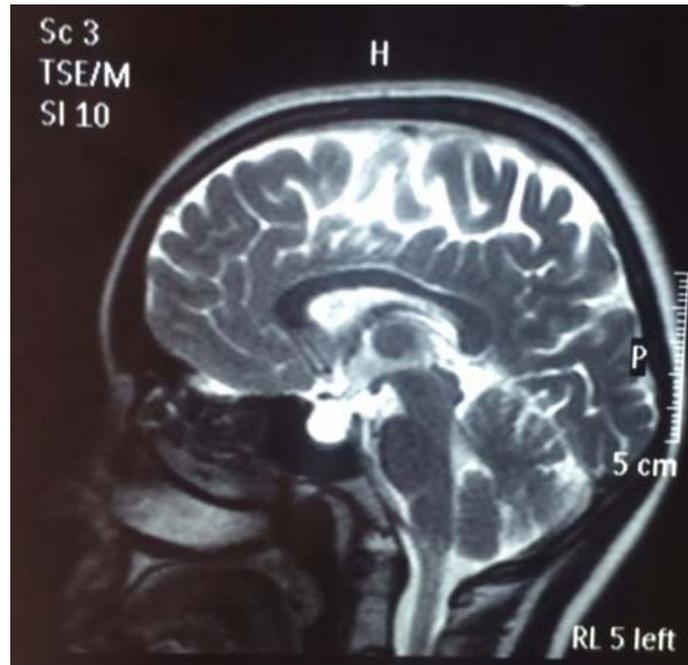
Sagittal T2-weighted MRI image before the shunt procedure shows, partial empty sella with flattened pituitary gland, and extension of suprasellar cistern to the widened sella.
